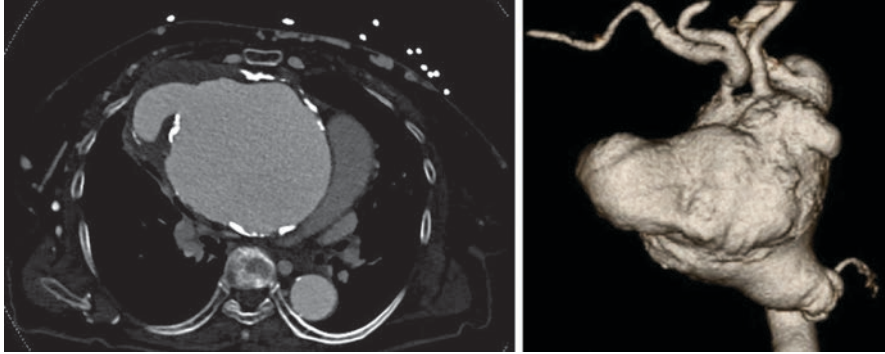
Large ascending and aortic arch aneurysm eroding through the chest wall on axial contrast CT scan effacing the pulmonary artery. 3D reconstruction of scan shows a normal aortic root and dilated ascending aorta that was measured at 13 cm. The aneurysm involves the aortic arch with arch vessels arising from the aneurysmal aorta
